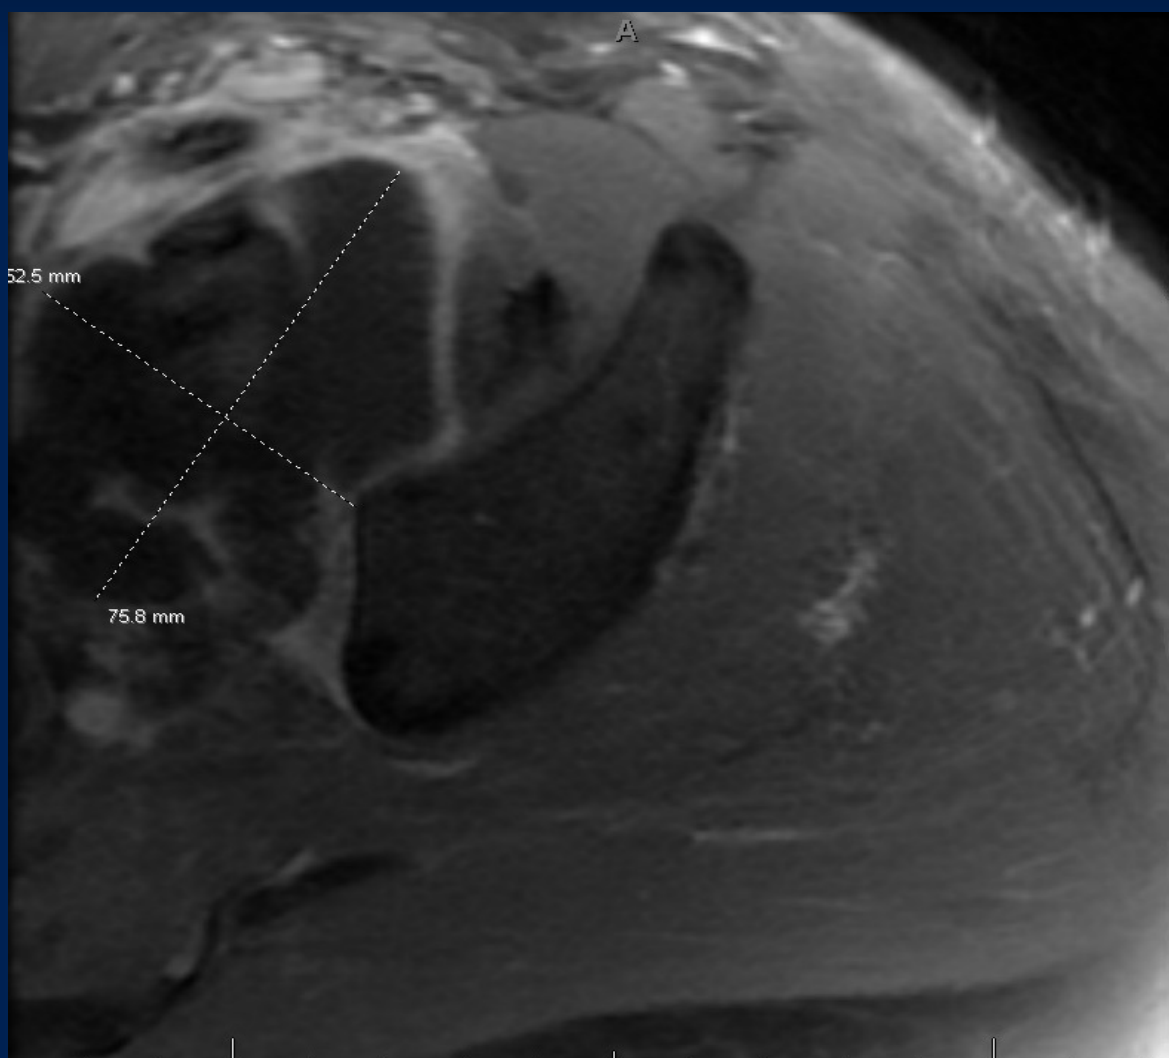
MRI Left Hip showing large iliopsoas bursa fluid collection concerning for an abscess
